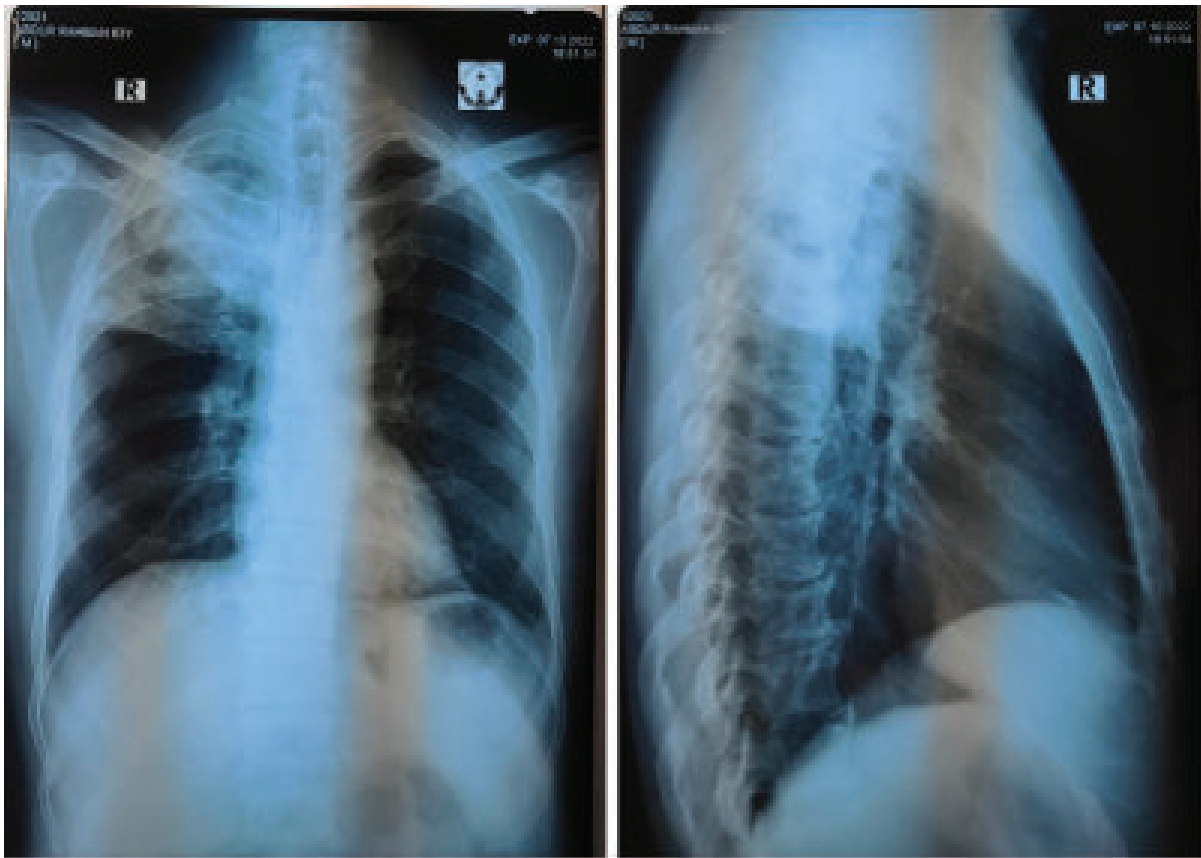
Chest X-ray postero-anterior and right lateral view showing consolidation at right upper chest
